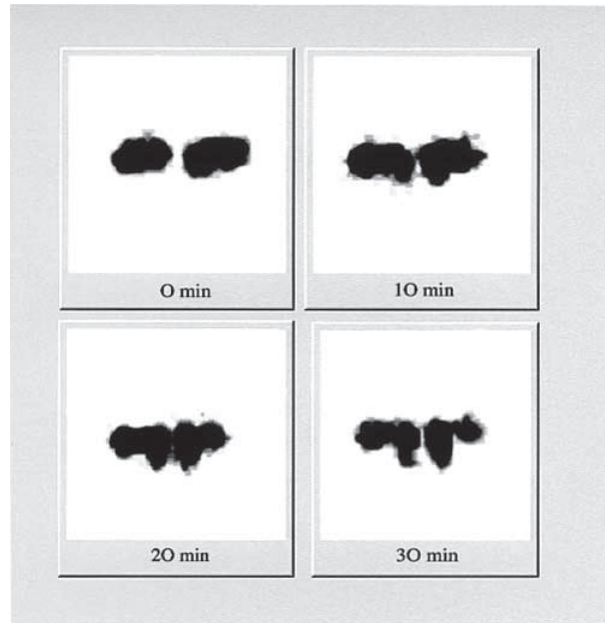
Lacrimal scintigraphy in a patient with dry eye syndrome.
